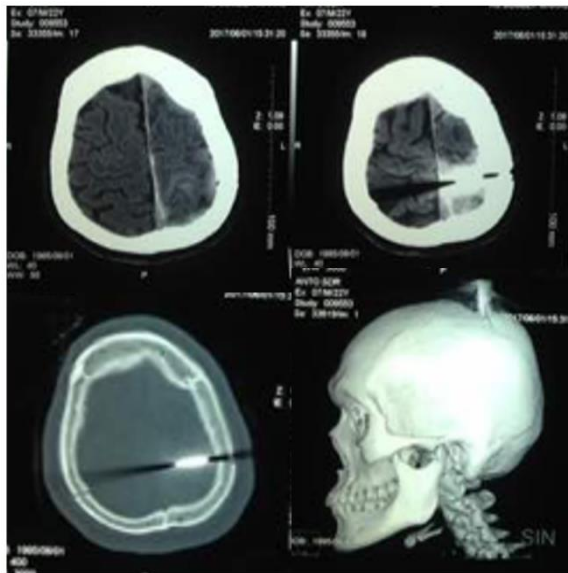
Computed tomography (CT) of the head and skull showed a hyperdense foreign body on the left side of the parietal region the associated presence of left cerebral contusion and subarachnoid hemorrhage
